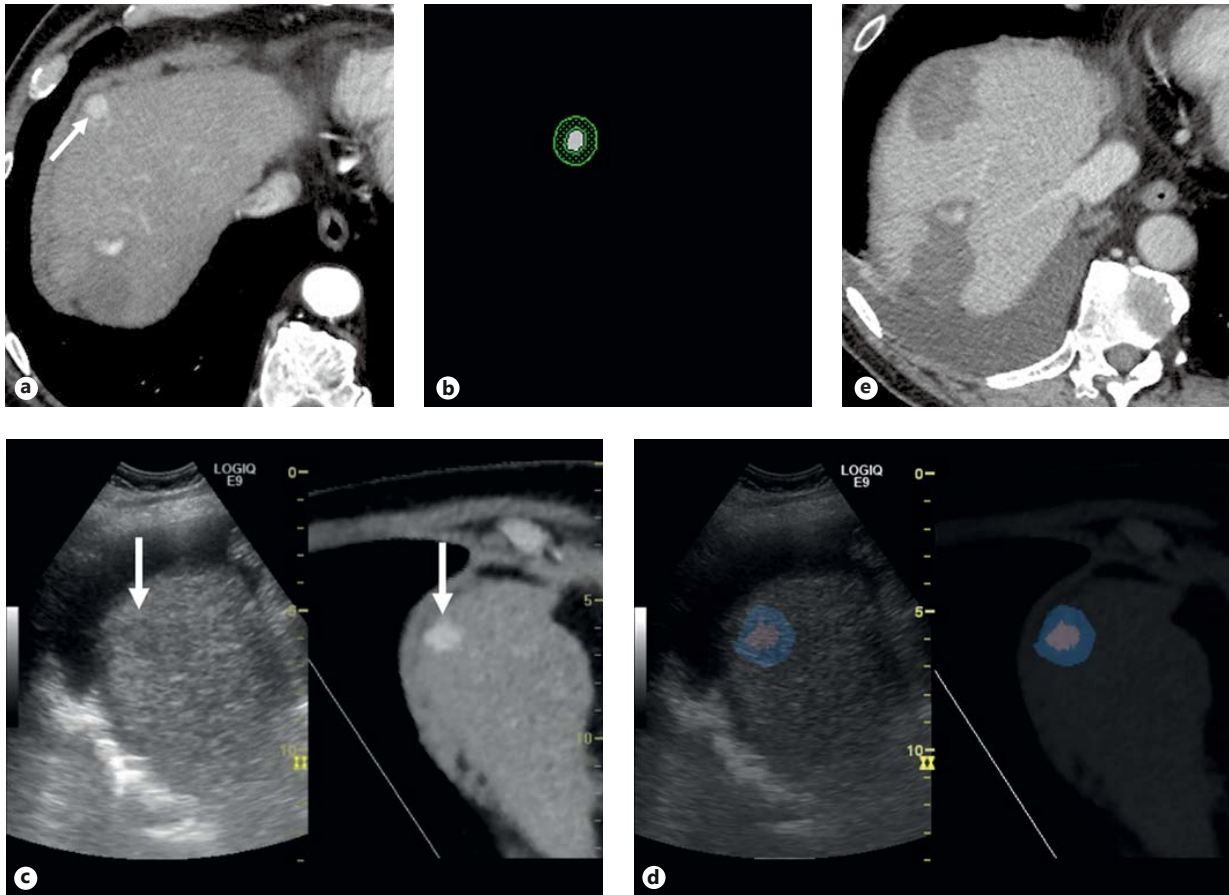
A 68-year-old man with hepatitis C-related cirrhosis and HCC underwent RFA with the extracted-overlay function using artificial ascites. a The arterial phase of dynamic CT showed hypervascular HCC (arrow), 15 mm in diameter, in segment VIII, which was used as a reference for CT/MR-US fusion imaging (Volume Navigation, GE Healthcare). b On an image-processing workstation (Advantage Workstation Volumeshare 4, GE Healthcare), the tumor was extracted from original data of the arterial phase of dynamic CT (white portion), and an ablative safety margin of 5 mm was added to the extracted tumor by tracing around it circumferentially with a virtual brush of 5 mm thickness (green portion). When a portion of the added margin protruded beyond the edge of the liver, it was trimmed. After the volume data of the extracted tumor
